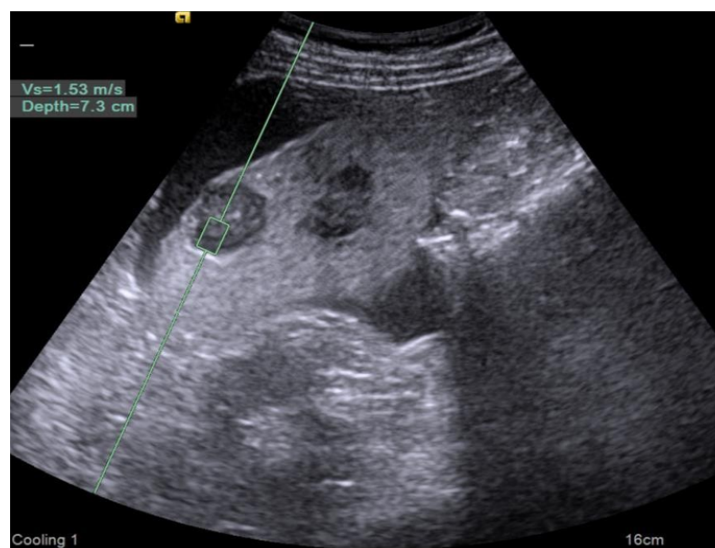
Ultrasound elastography in a case of cirrhosis
